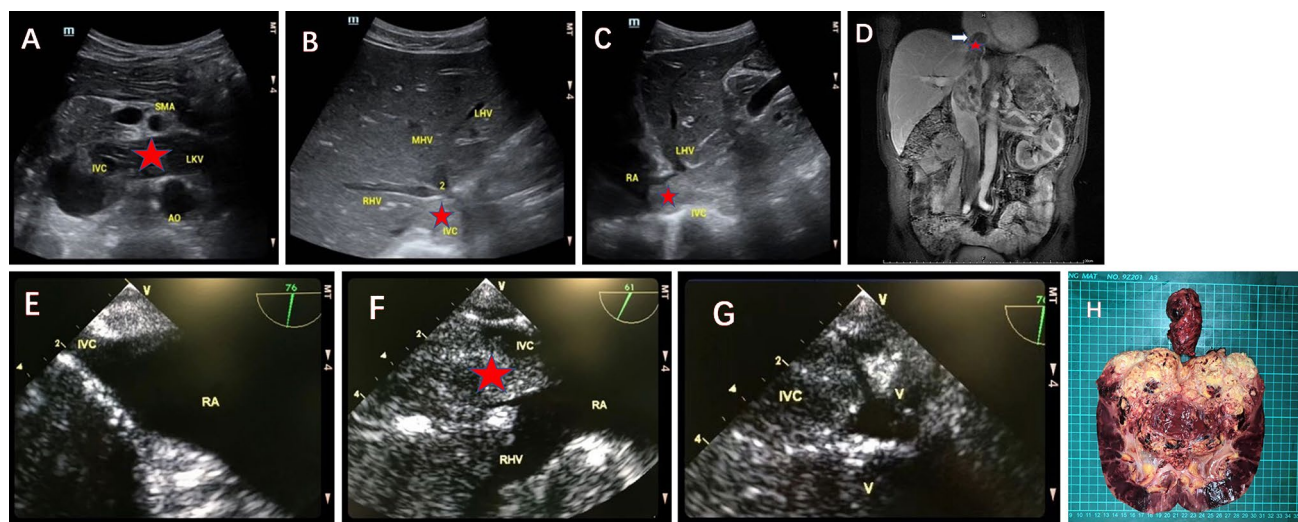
Preoperative images of thrombus Level IV (a–d): ultrasound image of tumor thrombus (asterisk) in LKV (a); ultrasound image of tumor thrombus (asterisk) in IVC at the level of second porta hepatis (b); ultrasound image of tumor thrombus (asterisk) in RA (c); magnetic resonance imaging of tumor thrombus (asterisk) (d). Intraoperative transesophageal echocardiography images of thrombus Level III (e–g): no tumor thrombus in RA was observed (e); the superior
